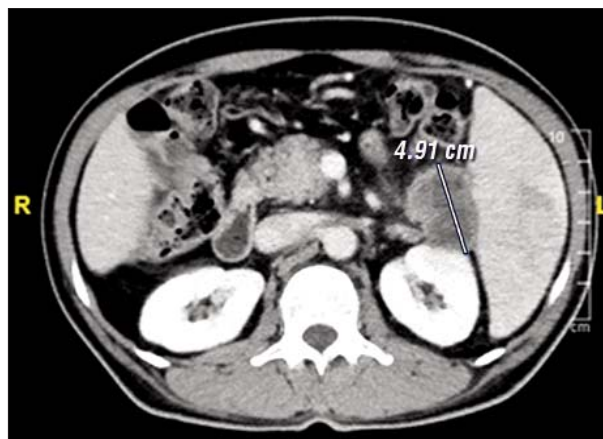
Staging CT scan prior to the neoadjuvant treatment showing the tumor mass at the pancreatic tail. The maximum diameter is 4.91 cm
